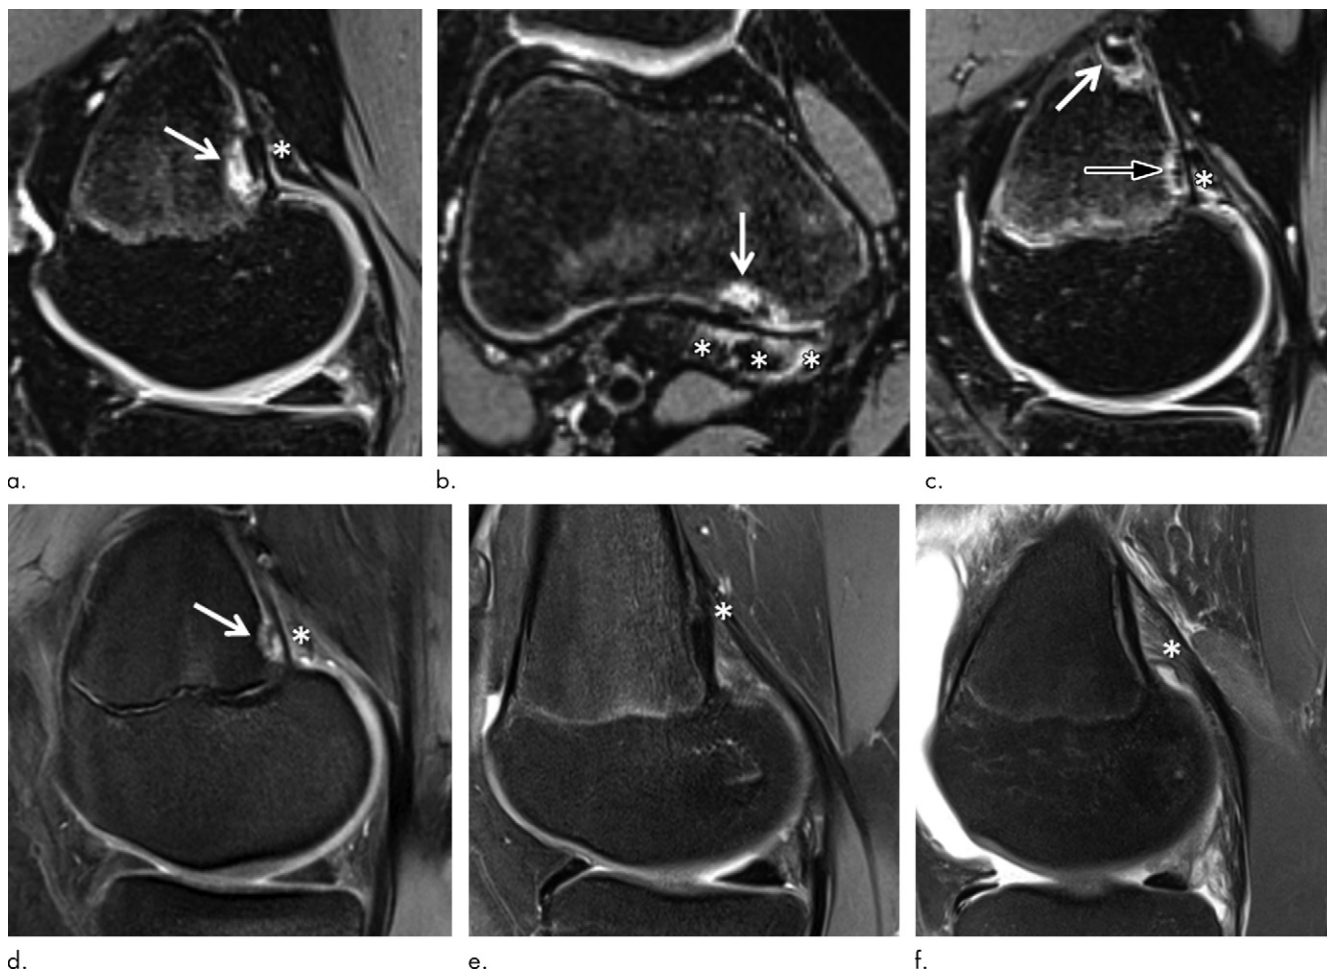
Images show examples of (a–d) distal femoral cortical irregularity (DFCI) at the tendon attachment of the medial head of the gastrocnemius muscle (MHG) and (e, f) knees without DFCI. (a, b) Sagittal (a) and axial (b) fat-suppressed T2-weighted MRI scans in 14-year-old female competitive skier show a 5-mm DFCI (arrow) at the distal MHG attachment (*). (c) Sagittal fat-suppressed T2-weighted MRI scan in another 14-year-old female competitive skier shows simultaneous DFCIs at the proximal (8 mm; white arrow) and distal (4 mm; black arrow) part of the MHG tendon attachment (*). (d) Sagittal fat-suppressed proton density-weighted MRI scan in 14-year-old female control participant shows a 4-mm DFCI (arrow) at the distal MHG attachment (*). (e, f) Sagittal fat-suppressed proton density-weighted MRI scans in 15-year-old female control participant (e) and 15-year-old male control participant (f) without a DFCI for comparison. The broad and fan-shaped appearance of the proximal MHG tendon (*) is especially well visualized in f because of edematous demarcation after knee trauma.
